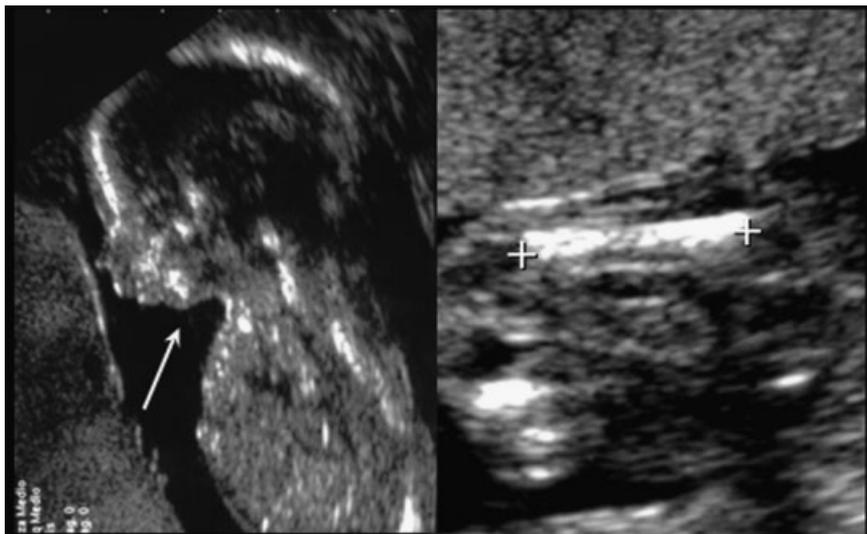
Ultrasound scan of fetus 3. Note micrognathia (arrow) and short femur.
